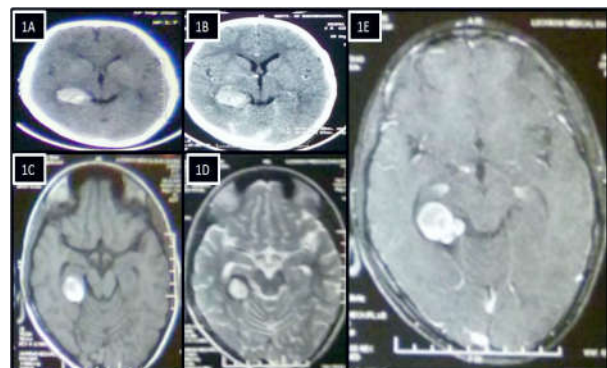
(A-B) Axial plain and contrast CT HEAD, (C) Axial MRI brain T1W1 images, (D) MRI brain T2W1, (E) MRI brain contrast showing lateral ventricle mass
